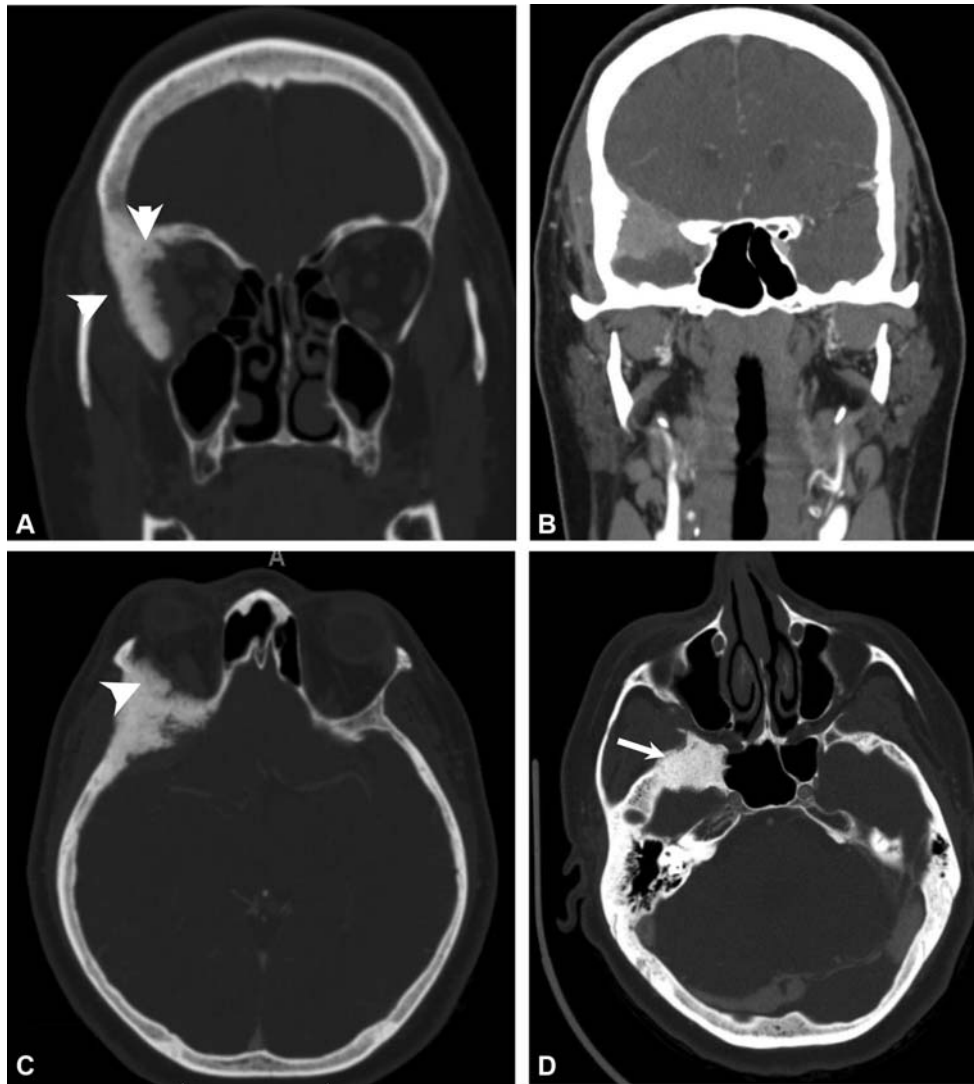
Preoperative coronal (A, B) and axial (C, D) CT showing significant osseous involvement by a sphenoidal meningioma, including the orbital roof and lateral orbit (arrowheads), but extending to the temporal squamosal bone and even the pterygoid base (arrow). CT, computed tomography.
